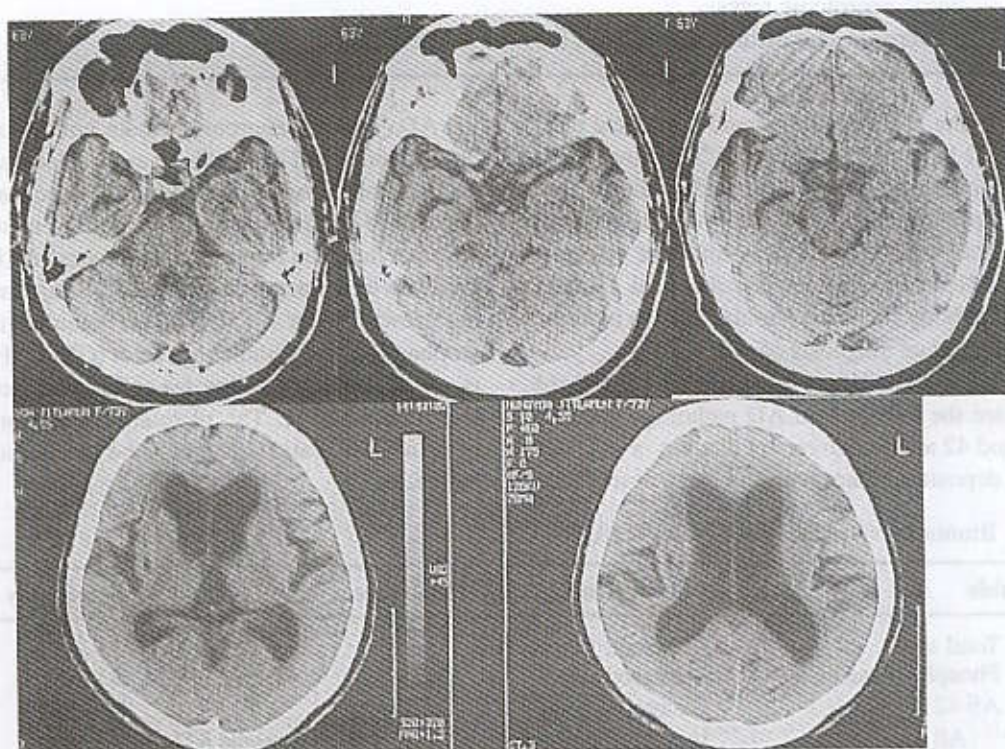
Axial CT brain scan of the patient showed asymmetrical atrophic changes of the right anterior temporal lobe with evidences of cortical reduction, widening of the right sylvian fissure and unilateral right temporal horn dilatation.
